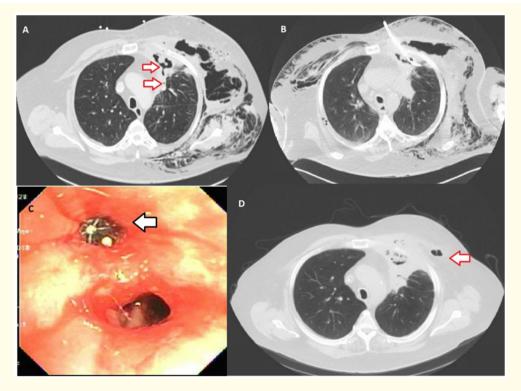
1A: Axial view of a chest CT showing extensive subcutaneous emphysema and a cavitary lesion with air fluid level in the apical-posterior segment of the left upper lobe (arrows) 1B: A 14Fr chest tube placed in the cavity to drain the purulent material and air, under CT guidance. 1C: Bronchoscopic image showing the endobronchial valve (EBV) placed in satisfactory position at the apical-posterior segment of the left upper lobe. 1D: Repeat chest CT one month following placement of the EBV. Note significant improvement of the fluid collection and subcutaneous emphysema seen in previous images. A chest CT six months later showed near complete resolution of these findings.
